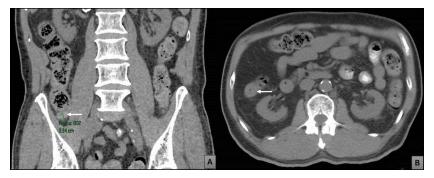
Abdominal computed tomography imaging to evaluate the appendiceal thickening in (A) coronal and (B) axial views. Arrows indicate areas of appendiceal thickening.
